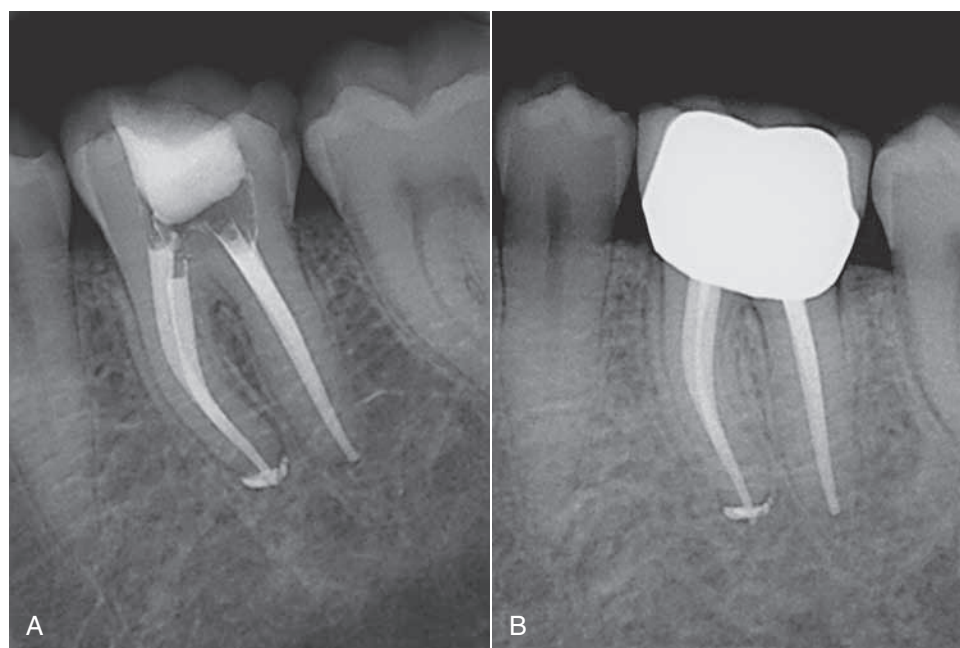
A, Resilon/Epiphany root canal system obturation. B, Recall radiograph shows healing after 7 months. (Courtesy Dr. Richard Rubenstein, Farmington, MI.)
